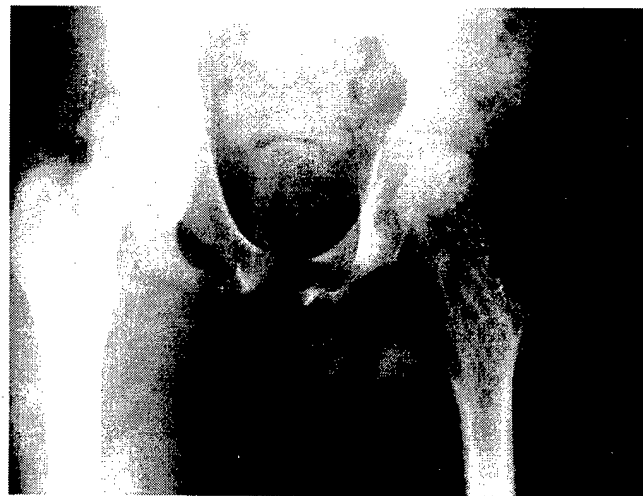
AP radiograph at 5 months post-injury suggesting an area of chondral collapse.
